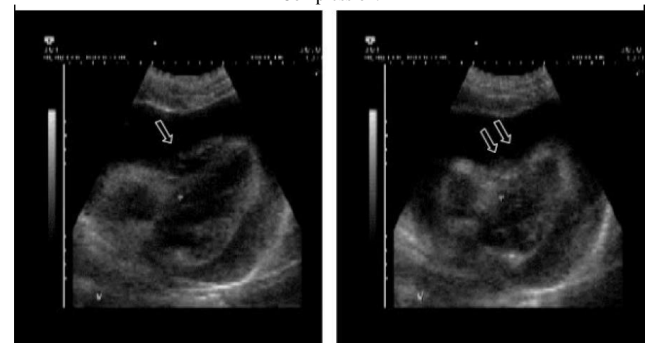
Ultrasound Image Showing Marked Pericardial Effusion with Ventricular Compression [Tamponade].
